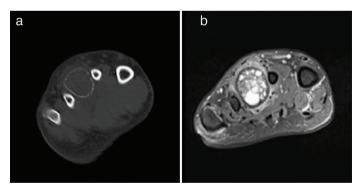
a-b. Axial views of non-contrast CT demonstrating lytic lesion in the third metatarsal with cortical thinning (a). Axial views of proton density MRI sequences reveal a lytic lesion in the third metatarsal bone (b).
